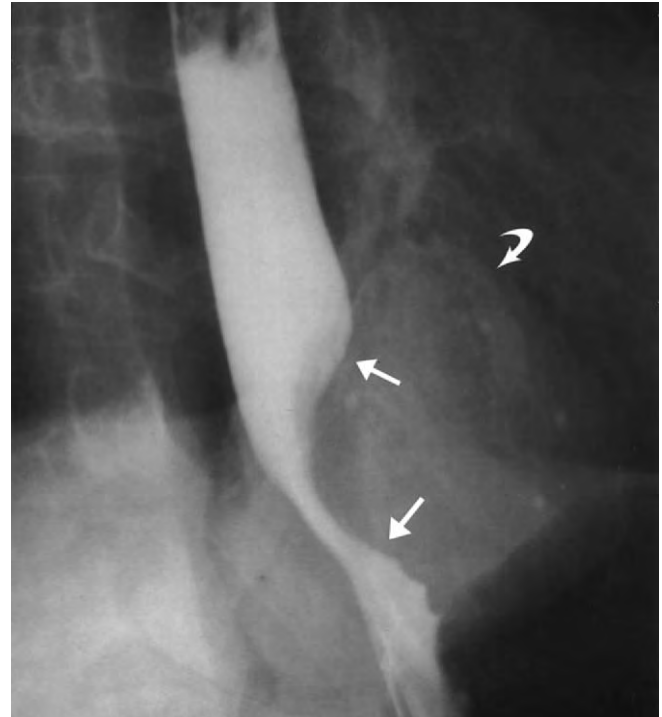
Asymptomatic 52-year-old woman with an abnormal chest radiograph. A barium esophagogram shows a mass effect in the lower esophagus on the left that is causing a smooth, sharply obtuse impression on the esophageal lumen (arrows). This was shown by biopsy to be a large benign leiomyoma with a prominent exophytic component (curved arrow).
